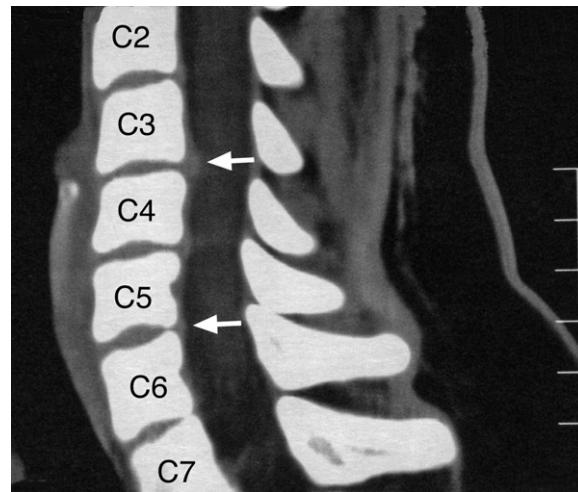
Cervical spine CT sagittal image. Note the 'mild posterior bulging at the C3–4 and C5–6 disc levels' (arrows).
